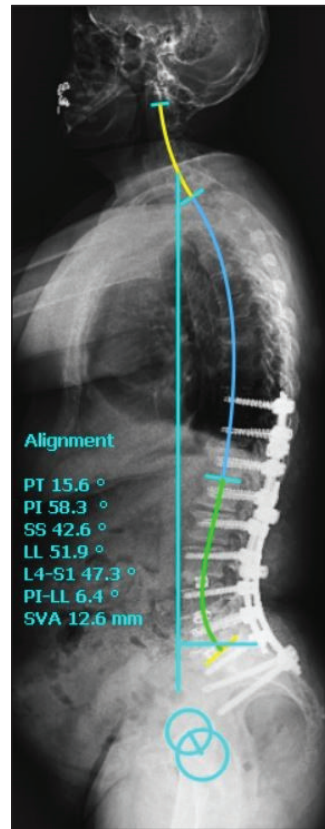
Postoperative lateral X-ray of the patient who underwent long-level fusion.
